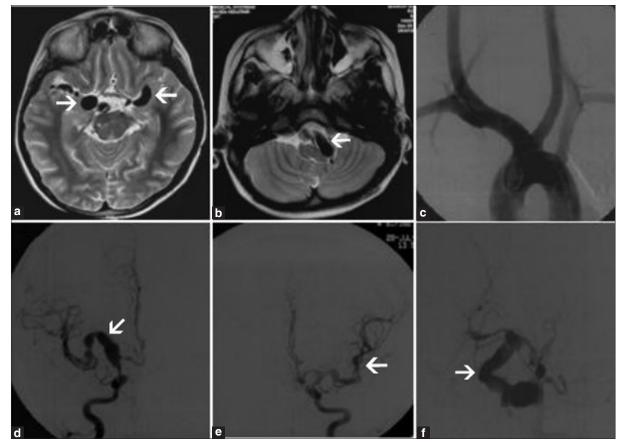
T2 magnetic resonance imaging of the brain shows aneurysmal dilatation of the right terminal internal carotid arteries (ICA), the left middle cerebral arteries (MCA) (a, arrows) and the left vertebral artery (b, arrow). Catheter angiogram shows normal aortic arch and its branches (c), aneurysmal dilatation of the right terminal ICA and the right MCA (d, arrow), aneurysmal dilatation of the left MCA (e, arrow) and the basilar artery (f, arrow)
